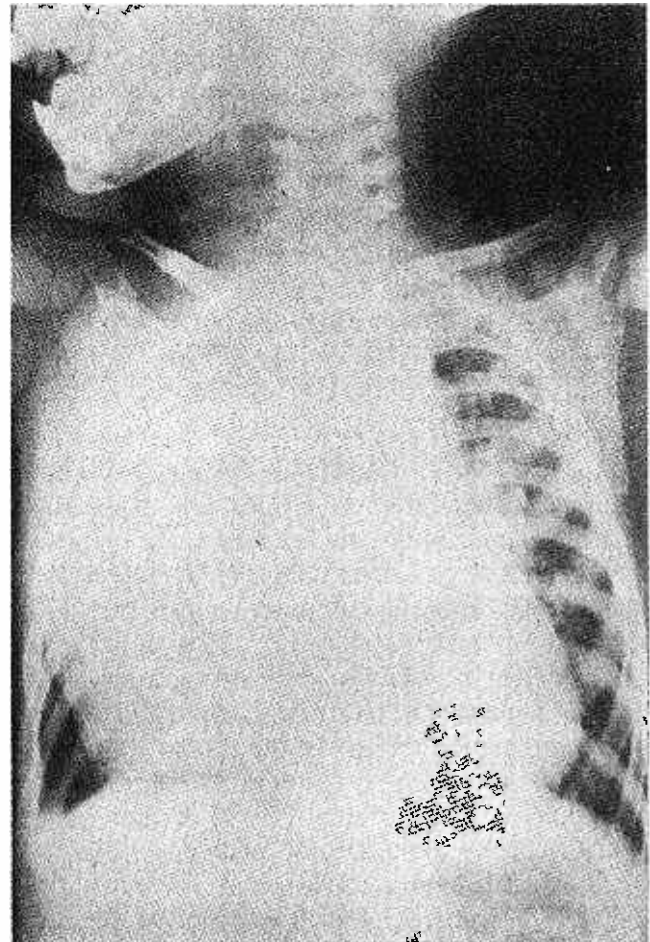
Chest X-ray showing teratoma of the thymus (A-P view).
